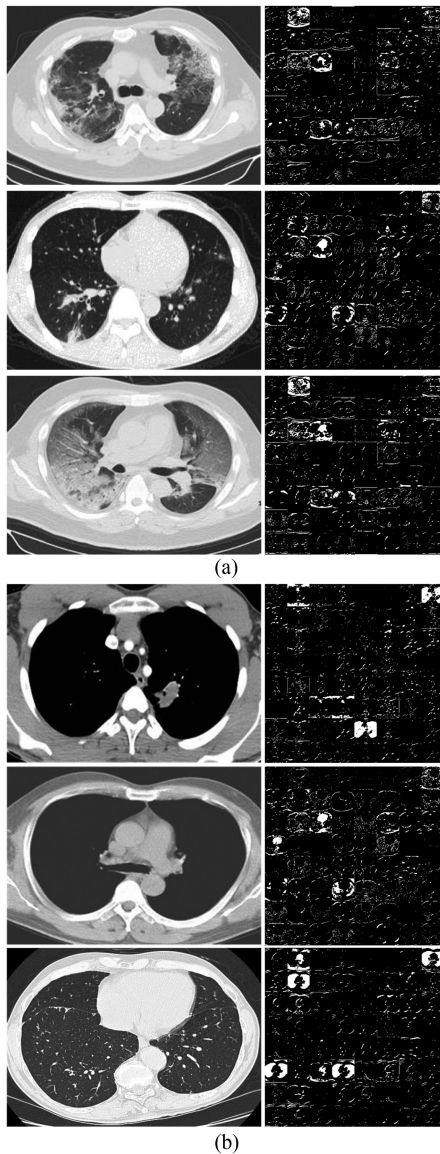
Feature map extracted by network. Our RLDD can map the input CT image to features that contain key information of the original CT image, such as texture, edge, and potential feature encoding, which can be used to infer the positive or negative case of the input CT images. (a) Positive case. (b) Negative case.
